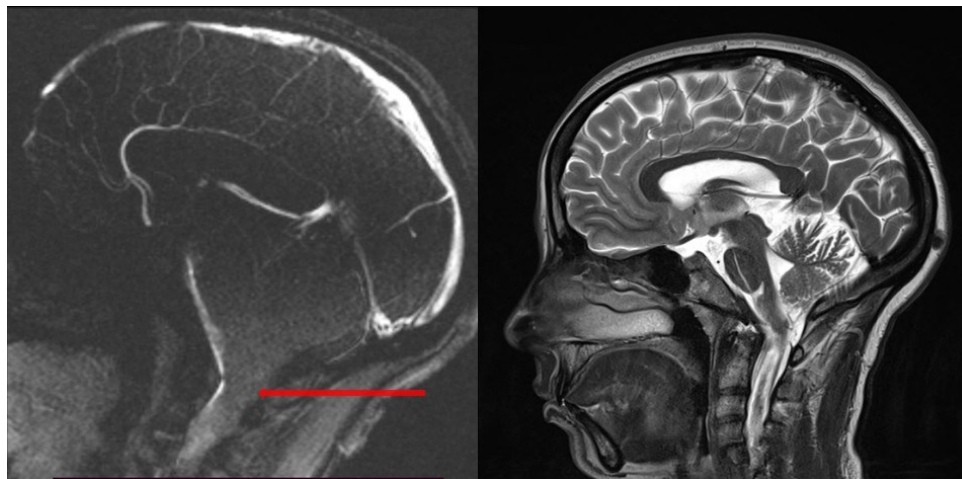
An MRI cine scan showing obstruction of CSF flow at the foramen magnum. (Red arrow)
